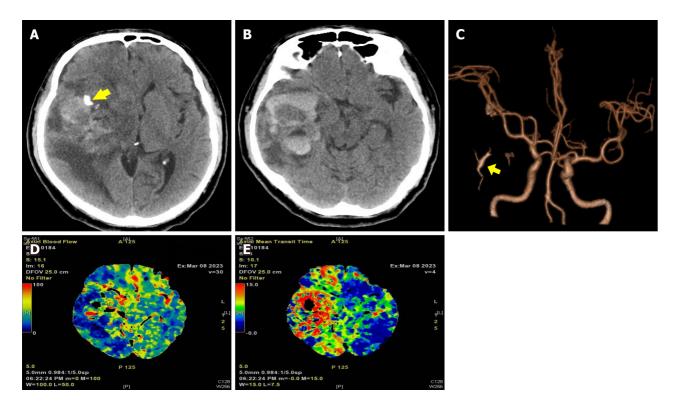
Preoperative neuroimaging. A and B: Cranial computed tomography revealed hemorrhage and edema in the right temporal lobe, calcification in the anterior portion of the mass (arrow), and a midline shift to the left; C: Computed tomography angiography revealed right middle cerebral artery elevation and an early drainage vein (arrow); D and E: Computed tomography perfusion imaging showed increased cerebral blood flow and mean transit time in the lesion area.
